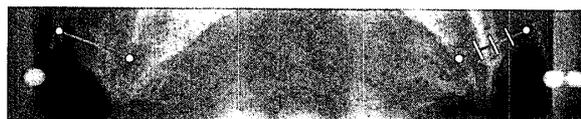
Scanned image of a submentovertex (SMV) radiograph. The yellow dots indicate the medial and lateral poles and the blue lines show the long axis of each mandibular condyle. The yellow lines indicate selected slice layers. The horizontal condylar inclination was corrected automatically, and so the tomographic projection was oriented perpendicularly to the condylar axis.
